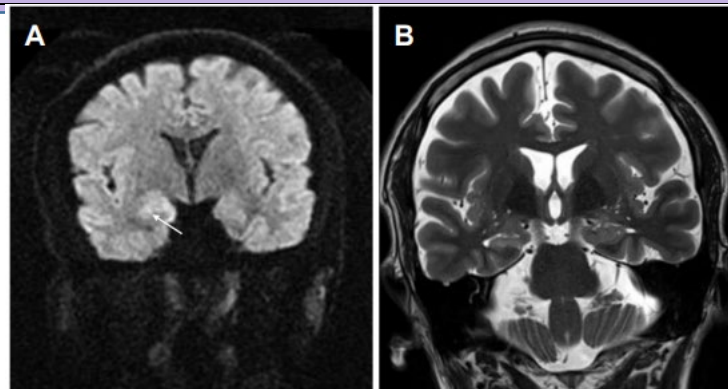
Subtle high signal intensity is observed in the right hippocampus (white arrow) on diffusion weighted image (A), which is not evident on T2-weighted image (B)
